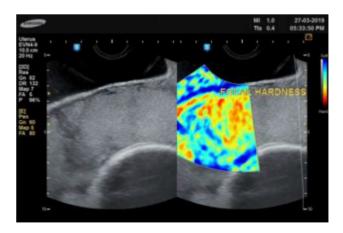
A case in which sonography showed no signs of placental invasion (left image) but elastography showed focal tissue hardness with confirmed intraoperative focal placental invasion
